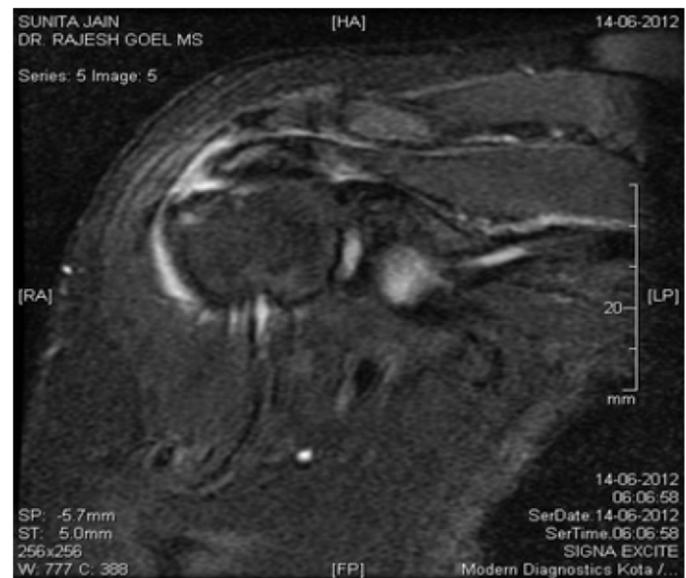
Coronal STIR MRI image showing hyperintense signal intensity at the site of insertion of supraspinatus tendon suggestive of full thickness tear of supraspinatus tendon.
